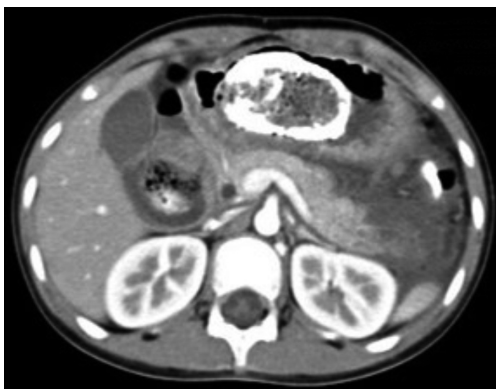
CT scan imaging. Enhancement scan imaging shows heterogeneous density and blurred margins of the pancreatic tail with blurred peripancreatic fat and fluid accumulation. CT, computed tomography.
